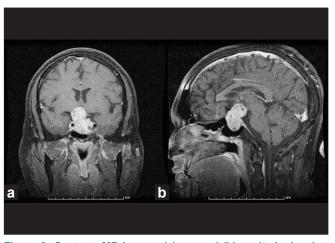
Contrast MR images (a) coronal (b) sagittal, showing a pituitary tumor with suprasellar extension and mass effect on the optic apparatus
